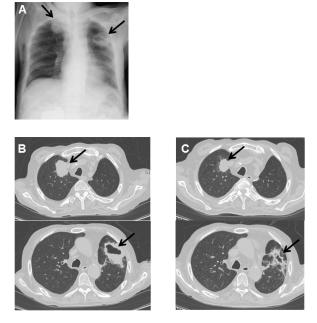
Chest X-ray and computed tomography findings in case 1. On admission, chest X-rays (A) and computed tomography (CT) (B) revealed a cavity in the upper left lung lobe and a mass lesion in the upper right lung lobe (indicated by arrows). Two weeks after initiation of trimethoprim/ sulfamethoxazole (TMP/SMX), a chest CT (C) scan revealed marked reduction in the size of both the cavity and the mass lesion (indicated by arrows). (A) Chest X-ray on admission (January 2013). (B) Chest CT scan on admission (January 2013). (C) Chest CT scan 2 weeks after initiation of trimethoprim/sulfamethoxazole (TMP/SMX).
